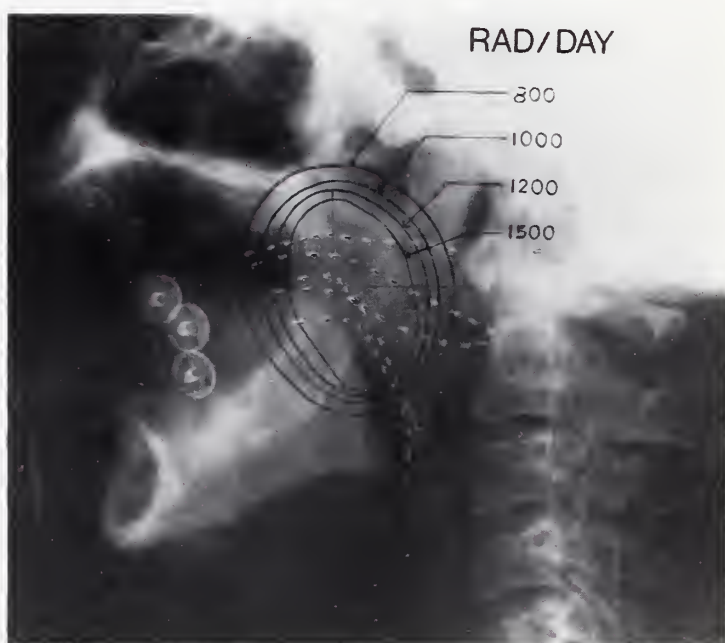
Lateral radiograph of an Ir^{192} implant of soft palate and the corresponding isodose curves. All 35 seeds were identified and marked for dosimetric computation (case 2).
